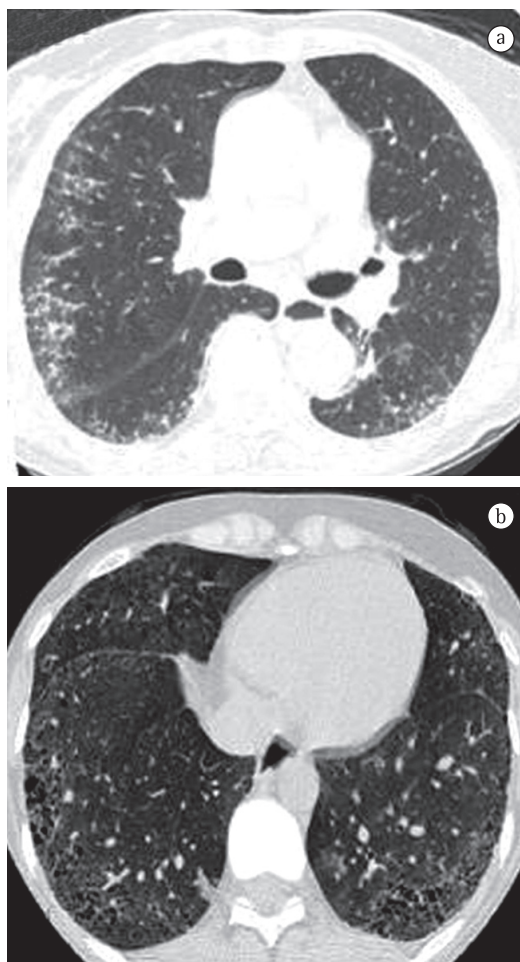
In a, HRCT of a 59-year old woman, showing septal thickening, small nodules, and ground-glass opacities predominantly in the peripheral and subpleural regions, being more pronounced on the right. In b, HRCT of a 38-year old woman, revealing bilateral areas of honeycombing with a predominance of cysts < 3 mm, located posteriorly and peripherally.
